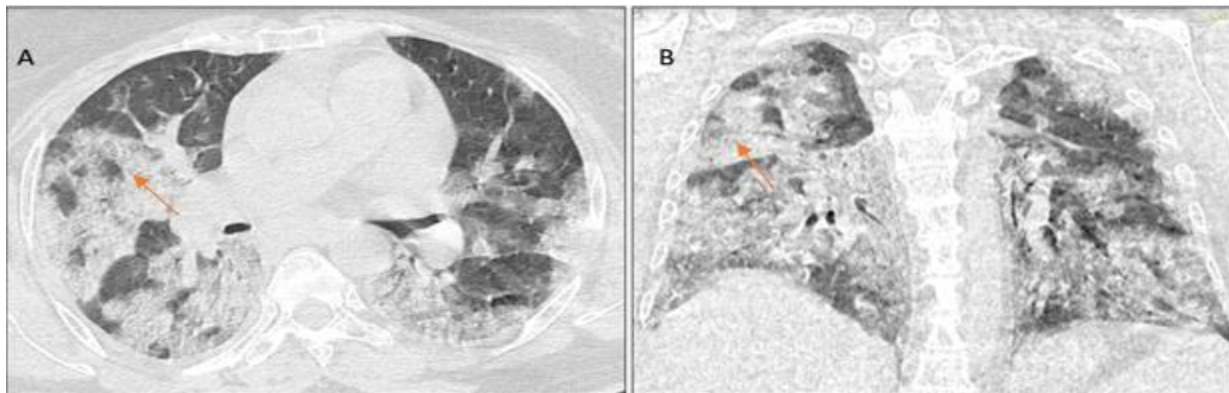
HRCT chest in a 63-year-old male patient A) axial and B) coronal section showing patchy central and diffuse areas of GGO with septal thickening (crazy paving-orange arrow)
